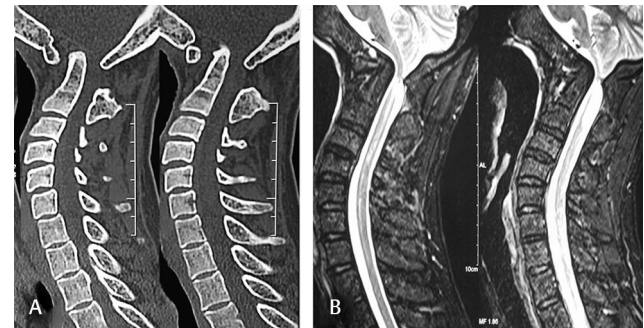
(A) Computed tomography of a patient showing basilar invagination with anterior atlantoaxial dislocation. (B) Magnetic resonance imaging of the same patient showing compression on brain stem.
